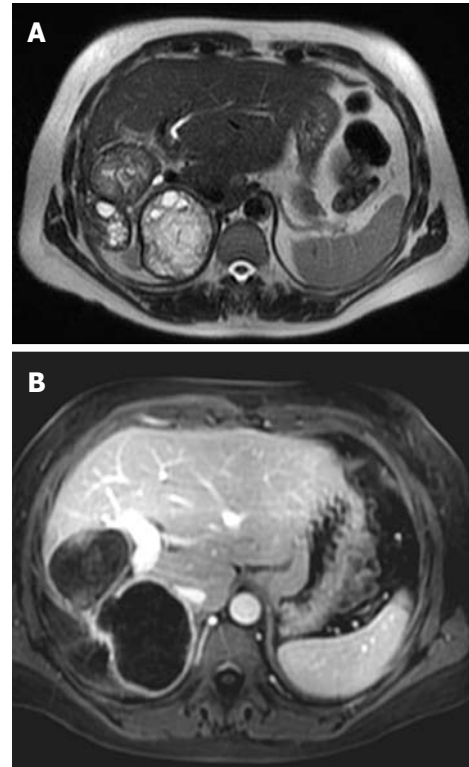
Axial T2-weighted and post-contrast images show the exophytic growth of hydatid cyst (type II) (A). After the injection of contrast media the septa and cyst wall enhance (B). Note the proximity of the cyst to the diaphragm which facilitates transdiaphragmatic thoracic involvement and to main portal vein.
